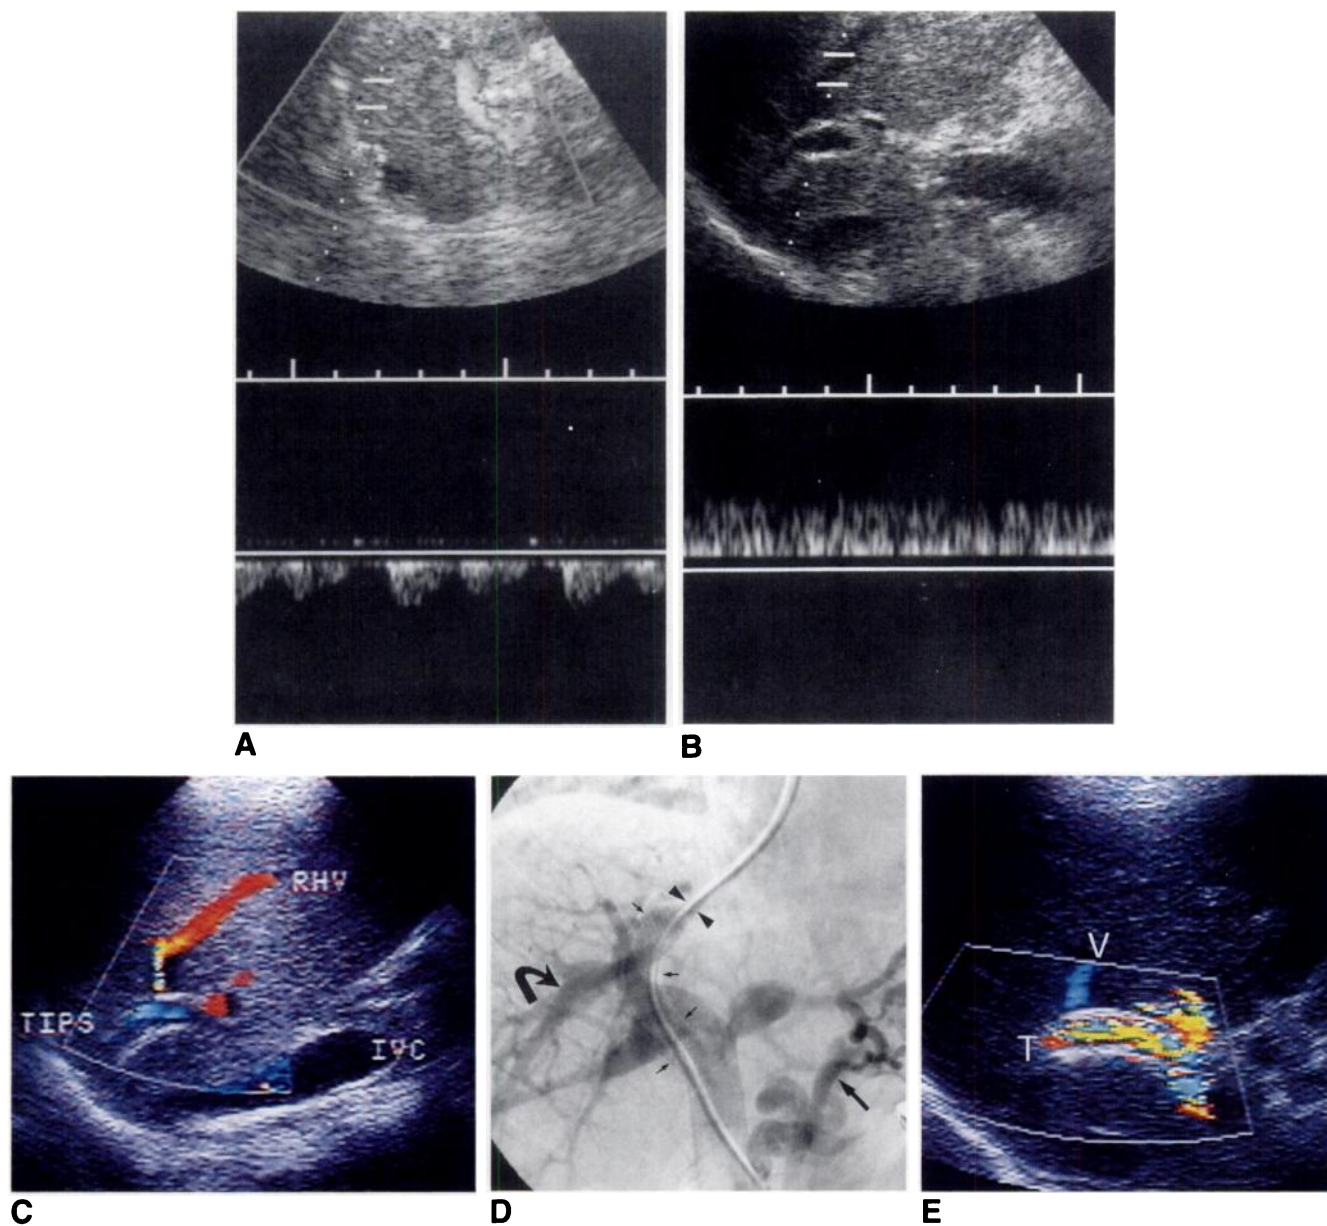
A, Doppler sonogram obtained 3 months after insertion of transjugular intrahepatic portosystemic shunt (TIPS) shows phasic blood flow in right hepatic vein (RHV). Doppler waveform is below baseline, indicating normal direction of venous flow away from transducer, toward inferior vena cava (IVC).
